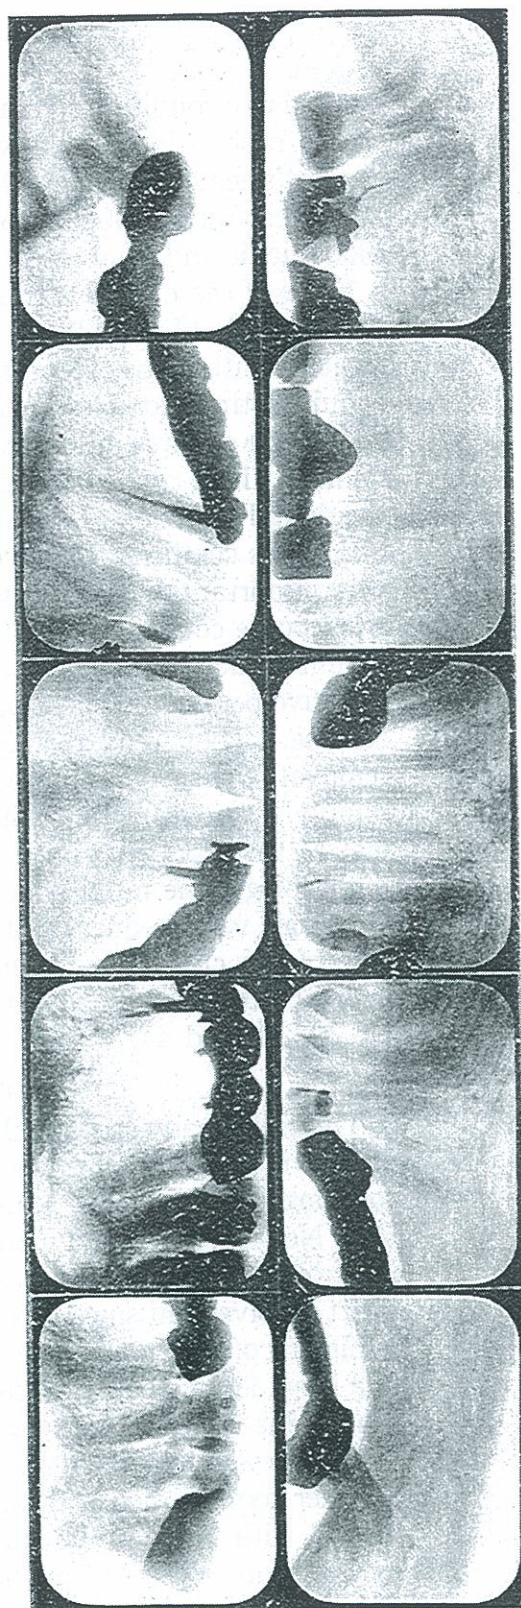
ROENTGENOGRAPHIC APPEARANCE OF TEETH OF PATIENT WITH MYOCARDITIS. CASE No. 1346.
